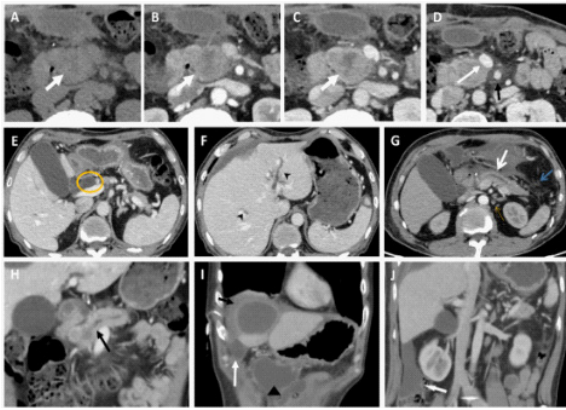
(a,b,c). The abdominal enhanced CT showed focal irregular mass in the head of pancreas (white arrows), with a maximum of 46 X 32mm, the CT value was 54 Hu in plain scan, 63 Hu in arterial phase and 85 Hu in venous phase. After contrast enhancement, the density was lower than the surrounding pancreatic tissue, with delayed reinforcement.
